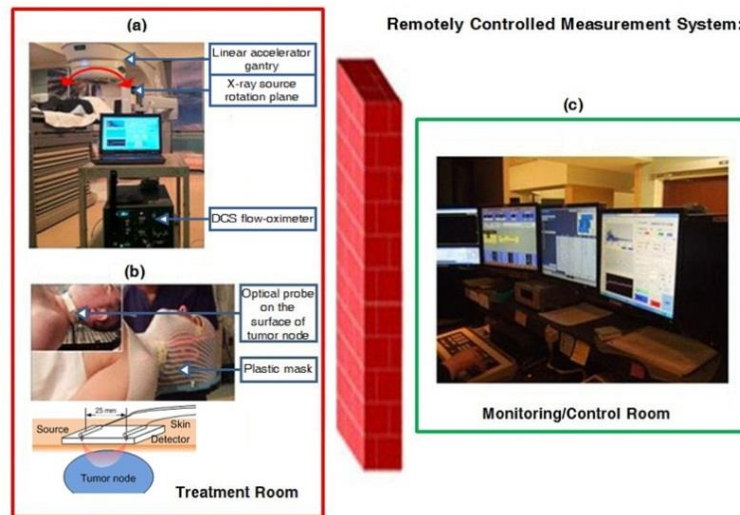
A remotely operated DCS flow-oximeter system for monitoring head/neck tumor hemodynamics during radiation delivery. (a) A DCS flow-oximeter was placed away from the rotation plane of x-ray beams in the treatment room. (b) A fiber-optic probe connected with the DCS flow-oximeter was fixed on the surface of cervical tumor node using a pre-molded plastic mask. (c) A computer in the monitoring/control room was used to remotely operate the DCS flow-oximeter in the treatment room.
